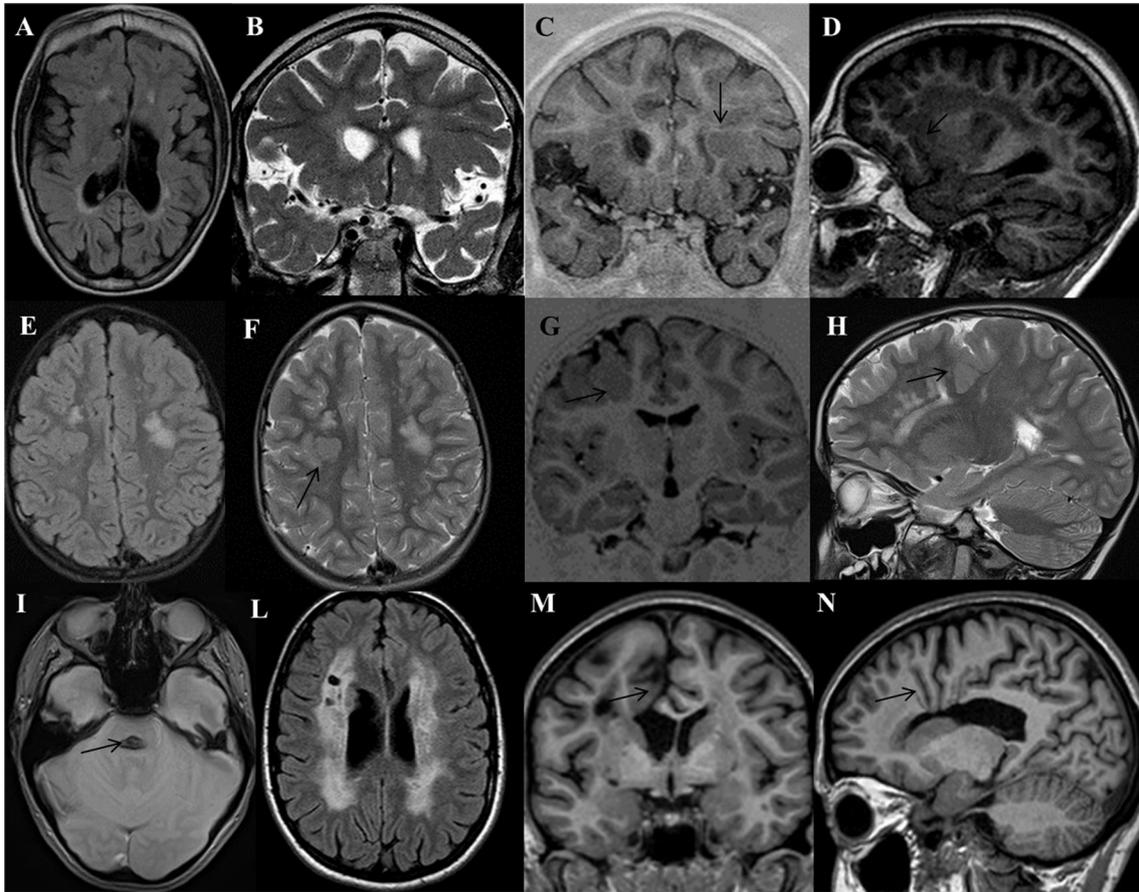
Non-contrast brain MRI: axial fluid-attenuated inversion recovery-FLAIR (A, E, L); coronal/sagittal T2-weighted turbo spin echo-TSE (B, F, H); coronal phase-sensitive inversion recovery-PSIR (C, G, M); axial T2-weighted fast field echo-FFE (I); sagittal magnetization-prepared rapid gradient echo-MPRAGE (D, N). Case 1 (A–D): bi-hemispheric leukoencephalopathy (A), left nucleo-capsular porencephaly (B) and left frontal insular polymicrogyria (C, D, black arrows); Case 2 (E–G): multifocal abnormalities of the white matter (E–F) and left frontal polymicrogyria (F, G, H, black arrows); Case 3 (I–N): old hematoma in the pons (I, black arrow), diffuse cerebrovascular lesions in the supratentorial white matter bilaterally (L), and mesial frontal schizencephaly (M, N, black arrow).
